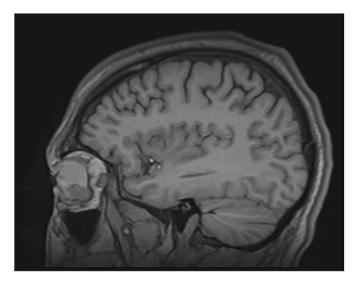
MRI brain without contrast, T1-weighted sagittal image showing inferior intraocular mass of left eye with extrascleral extension.
